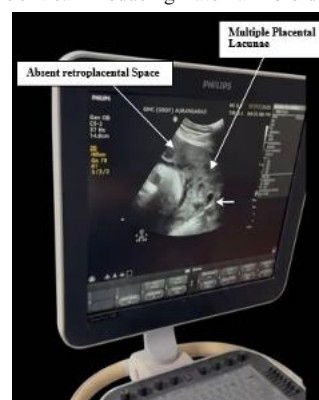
Ultrasonographic image showing placenta previa with features suggestive of placenta accreta spectrum.
